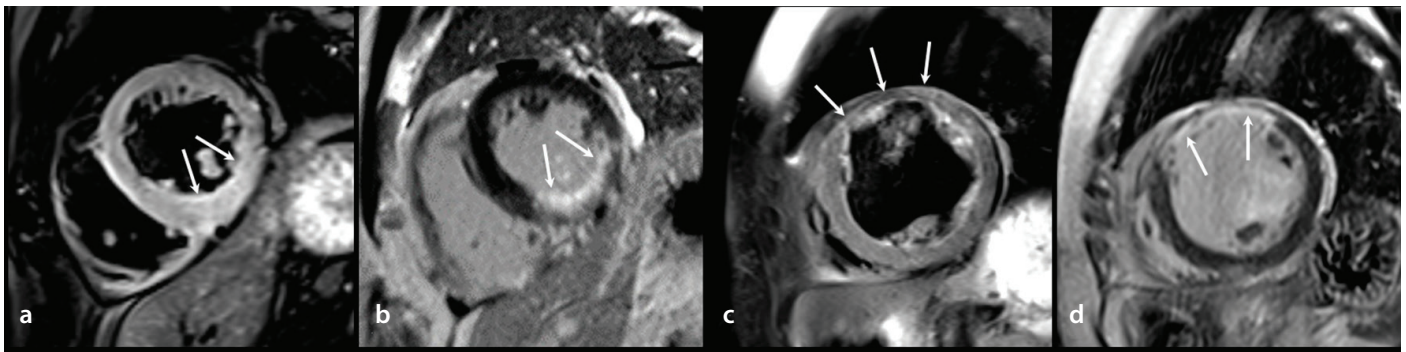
Difference in CMR imaging findings between acute and chronic MI. (a, b): Short-axis T2-weighted STIR (a) and LGE (b) images show transmural high signal intensity (a) and delayed enhancement (b) in the mid-inferior and inferoseptal LV segments without myocardial thinning (arrows), consistent with acute MI. (c, d): Short-axis T2-weighted STIR (c) and LGE (d) images show a normal T2 signal with myocardial thinning (c) and transmural delayed enhancement (d) in the mid-anterior LV segment (arrows), consistent with chronic MI. Although T2-weighted STIR alone cannot reliably distinguish acute from chronic MI, the combination of LGE and T2-weighted STIR enables the identification of infarct-related myocardial edema indicative of acute MI. CMR, cardiac magnetic resonance; MI, myocardial infarction; LV, left ventricular; LGE, late gadolinium enhancement; STIR, short tau inversion recovery.
